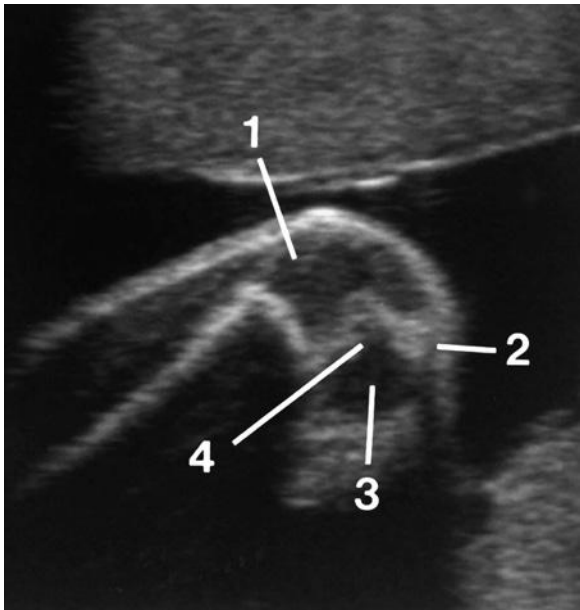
Midsagittal sonogram of the fetal knee in flexion shows the distal femoral epiphysis (1), patellar ligament (2), and proximal tibial epiphysis (3). These three structures marginate the knee joint. Within the knee joint is a large quantity of highly echogenic tissue, presumably synovium. Clearly outlined by the bright "synovium" is the cruciate ligament (4).
